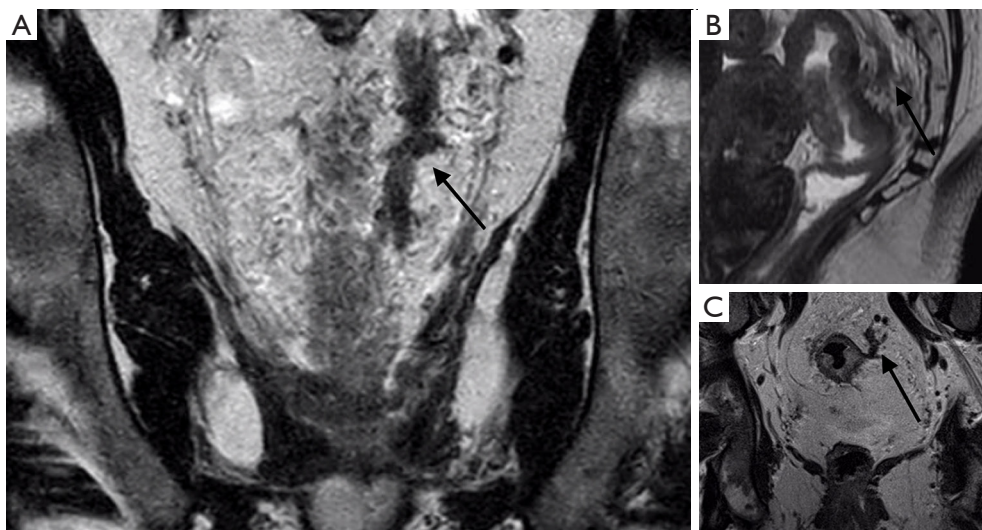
Rectal MRI demonstrates mrEMVI in three different patients (A,B,C). Extensive large vessel mrEMVI is shown in (A). Neoadjuvant chemoradiotherapy is indicated.
